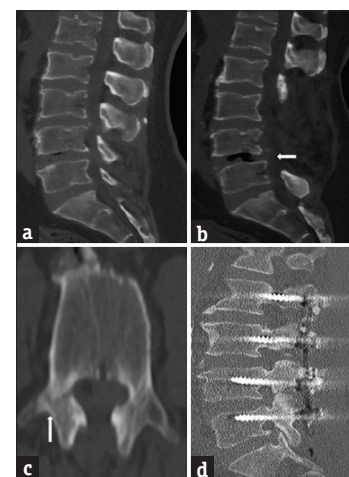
Computed tomography before first operation determined lumbar stenosis (a). One year after the total laminectomy surgery, L4-5 listhesis and L4 vertebra pedicle fracture occurred after falling (white arrows) (b and c). Pedicle screws were seen after second surgery (d)
